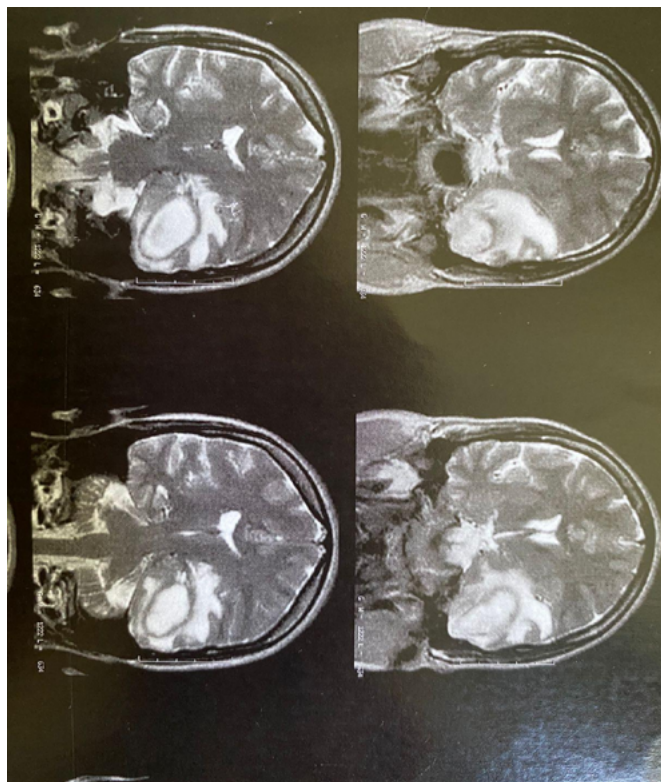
Contrast-enhanced cranial magnetic resonance imaging performed on January 13, 2020.
